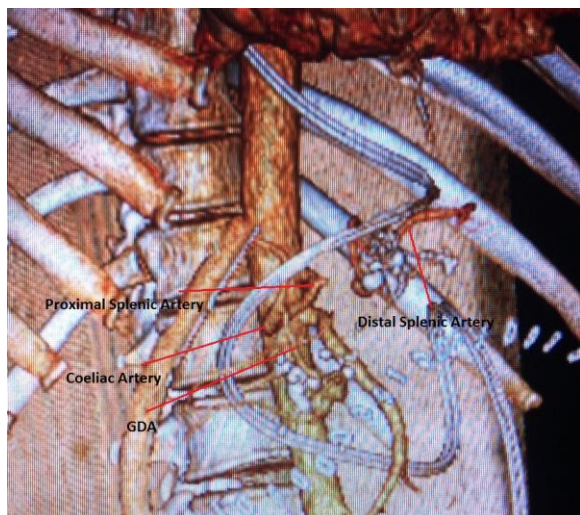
CT Angiography with 3D reconstruction showing filling up of distal splenic artery from pancreatic collaterals.
